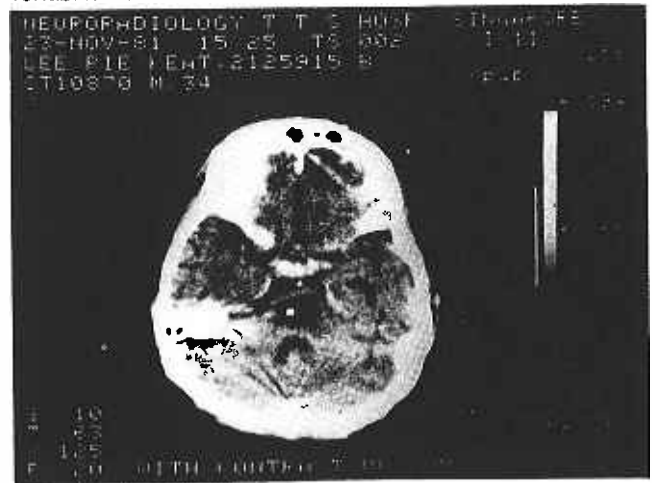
First CT Scan shows a large hypodense area in the middle of the pons. There is no enhancement after fusion of contrast medium.
